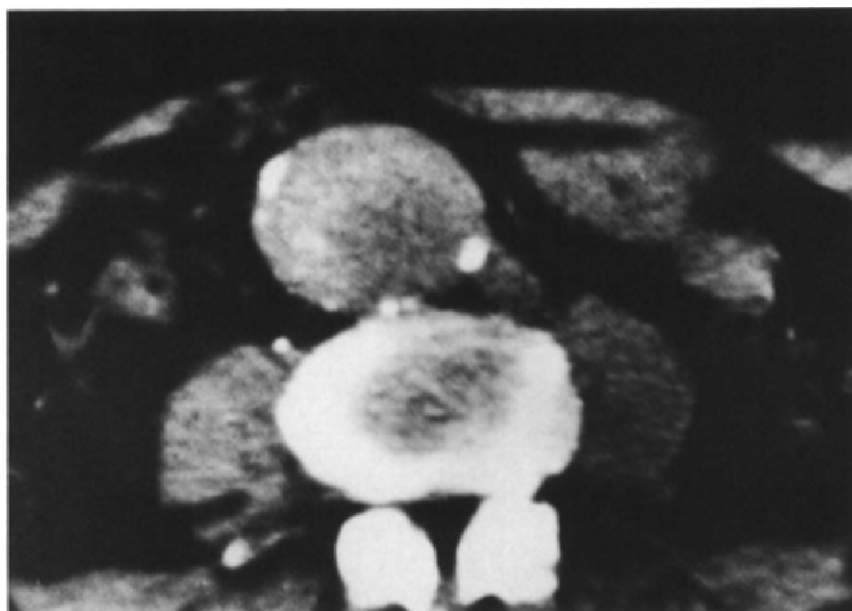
Computed tomographic scan of Patient Number 1.
